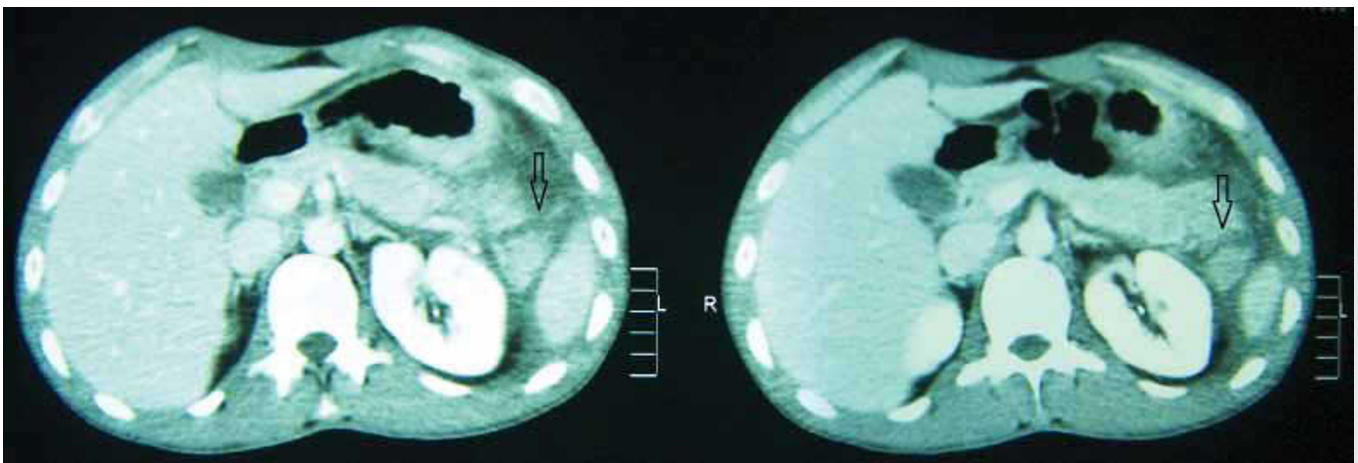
Axial contrast enhanced CT image of the abdomen demonstrating pancreatic parenchymal contusion, laceration and transection at the tail of pancreas (arrows).
